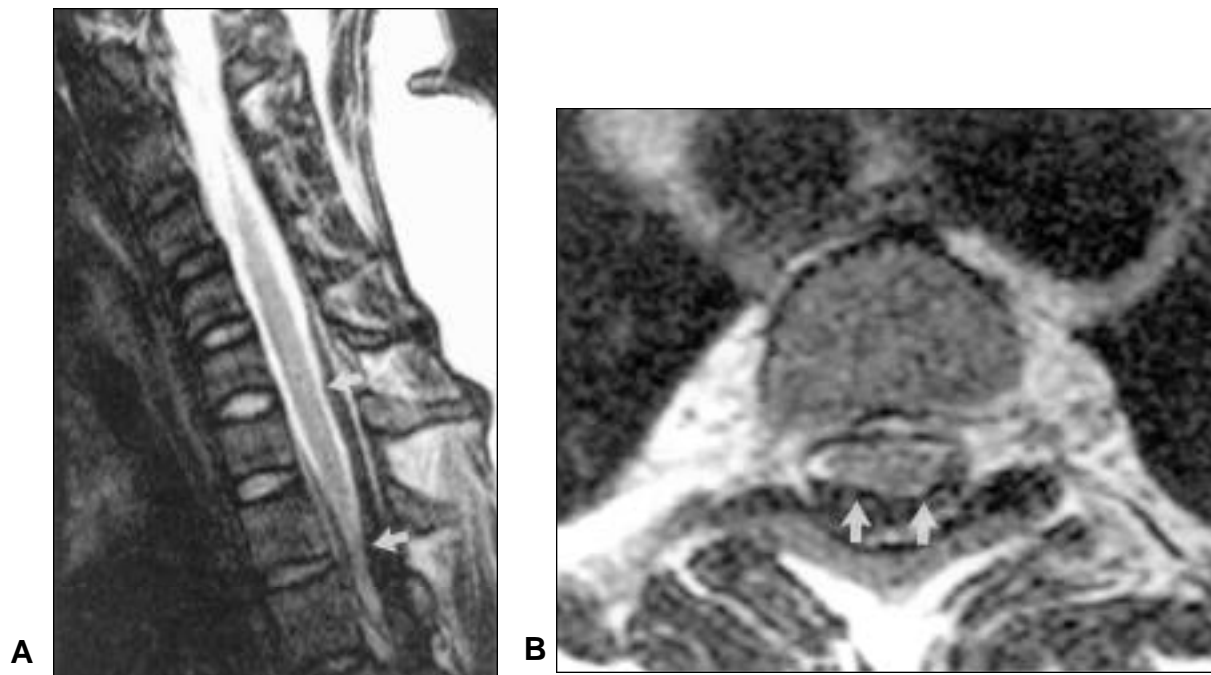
Patient 2. Sagittal (A) and axial (B) T2-weighted fast spin-echo images of the lower cervical and upper thoracic spine show markedly thickened dura which appears hypointense (arrows), causing mild spinal cord compression.
